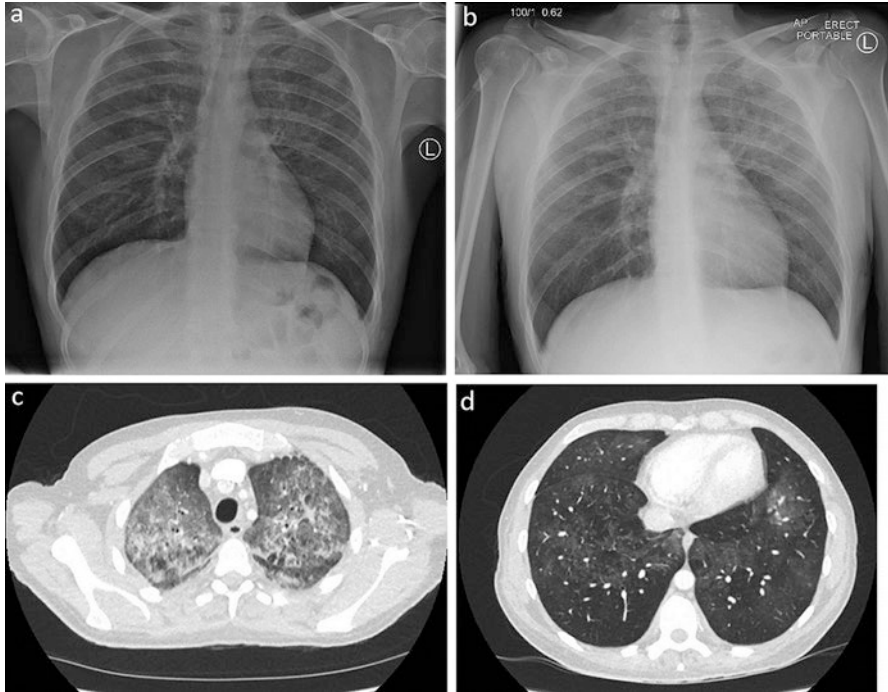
(a) X-ray of the chest revealing bilateral apical ground glass alterations. (b) An X-ray of the chest reveals increasing bilateral upper lobe airspace shadowing, (c and d) chest computed CT demonstrating extensive ground glass alterations with basal sparing, reprinted with permission [32]
